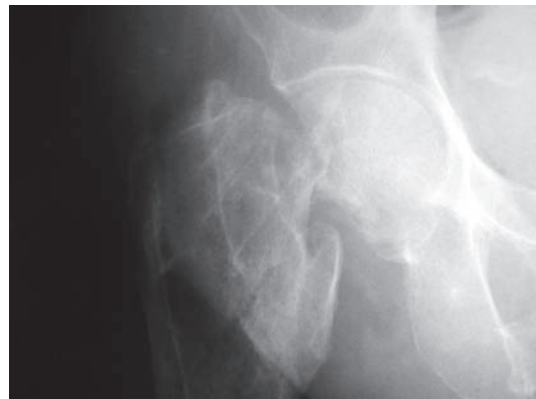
X-ray images at frontal plane (A) and lateral plane (B) of the hip showing transtrochanteric fracture in union process.
